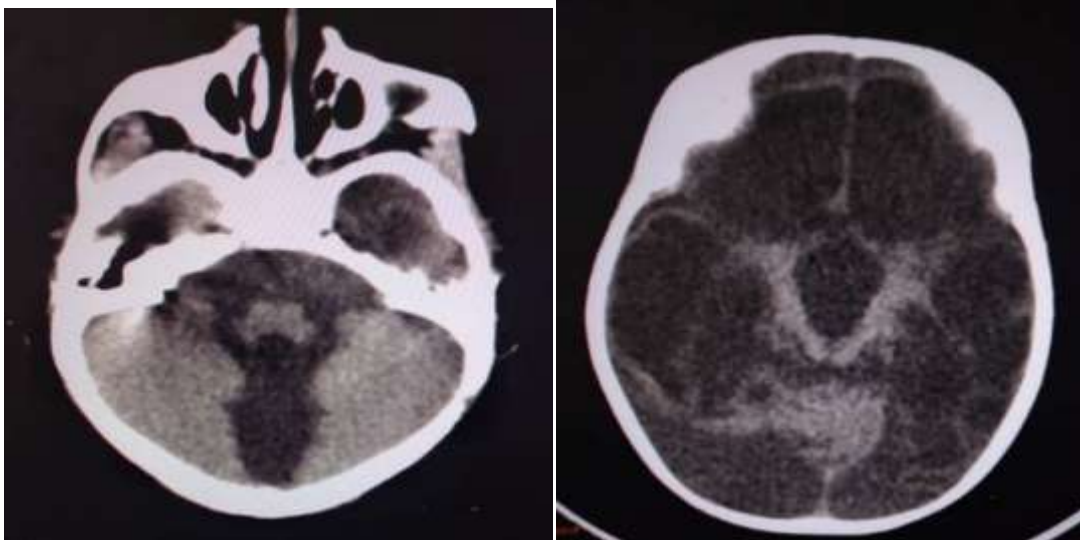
Axial CT sections without PDC injection showing areas of bilateral hemispherical cortico-subcortical hypodensity with porencephalic cavities associated with significant enlargement of the furrows, lateral ventricles, V3 and V4 (multicystic encephalopathy with significant cerebral hypoxia).
